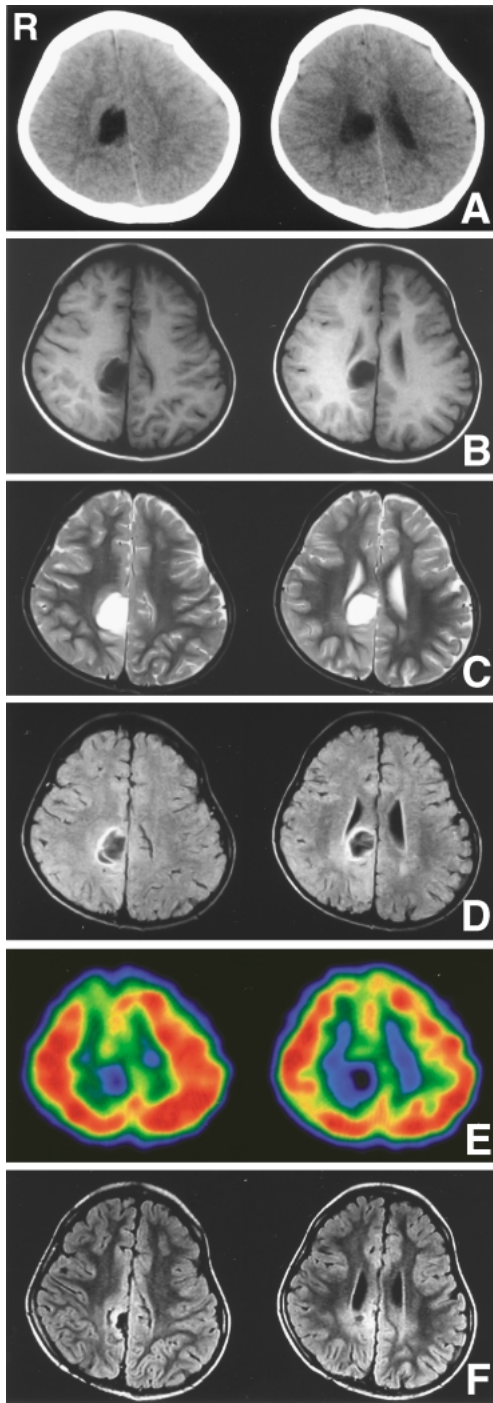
A-E: Preoperative computed tomography scans (A), T₁-weighted (B), T₂-weighted (C), and fluid-attenuated inversion recovery (D) magnetic resonance images, and technetium-99m ethyl cysteinate dimer single photon emission computed tomography images (E) showing a tumor mass in the right cingulate gyrus. F: Two years later, postoperative fluid-attenuated inversion recovery magnetic resonance images revealing evidence of resection of the tumor.
